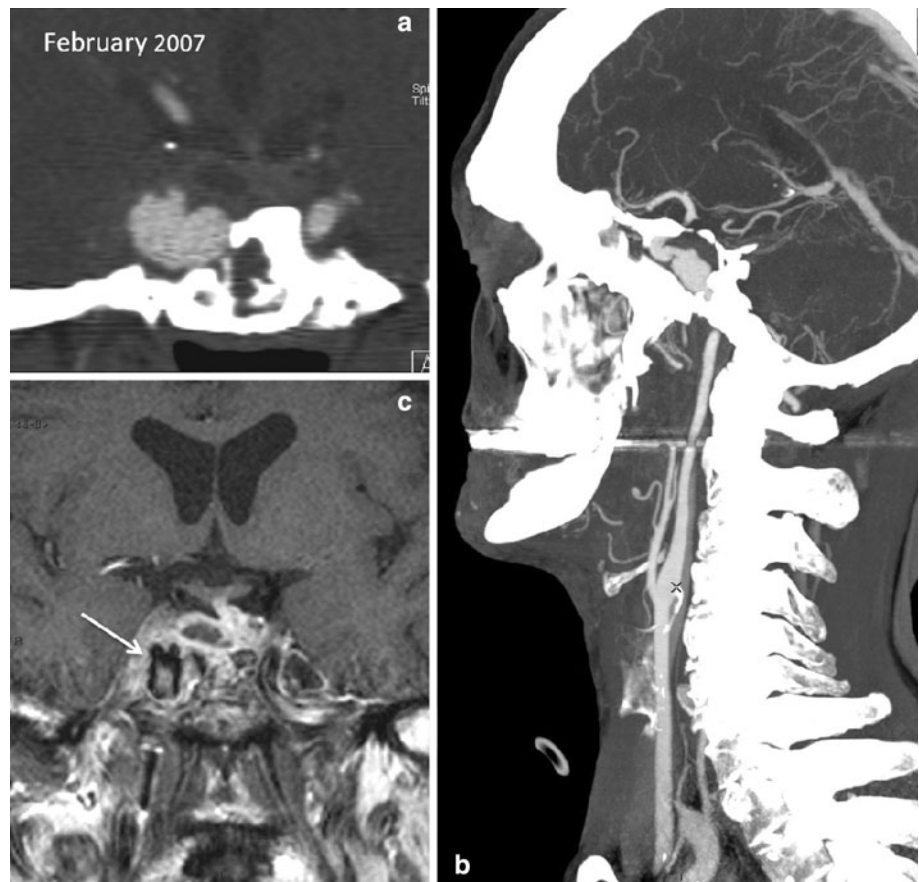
Imaging work-up in February 2007 demonstrating the onset of intracavernous mycotic aneurysm of the ICA: CT angiography in a (coronal reformat at sphenoid level) and b (sagittal reformat covering head and neck); focal enlargement of the lumen of the vessel is obvious. Contrast-enhanced coronal T1-weighted view in c showing enlarged lumen of the right ICA and a turbulence artifact within it
